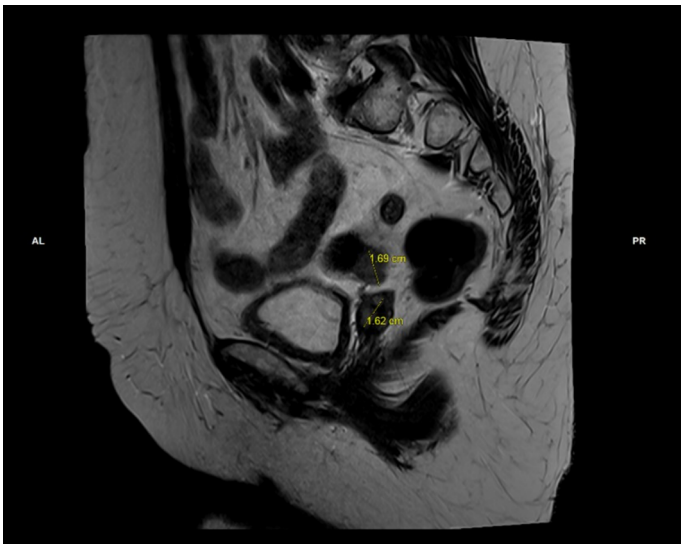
Cross-sectional T1 weighted MRI of patient's pelvis showing a 1.7cm serosa nodule on the mid sigmoid colon – in very close proximity of the vaginal stump.
